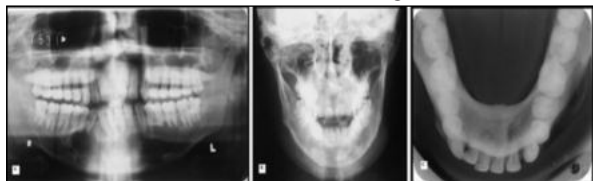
Radiographs Shows KCOT At The Time Of Initial Presentation.
